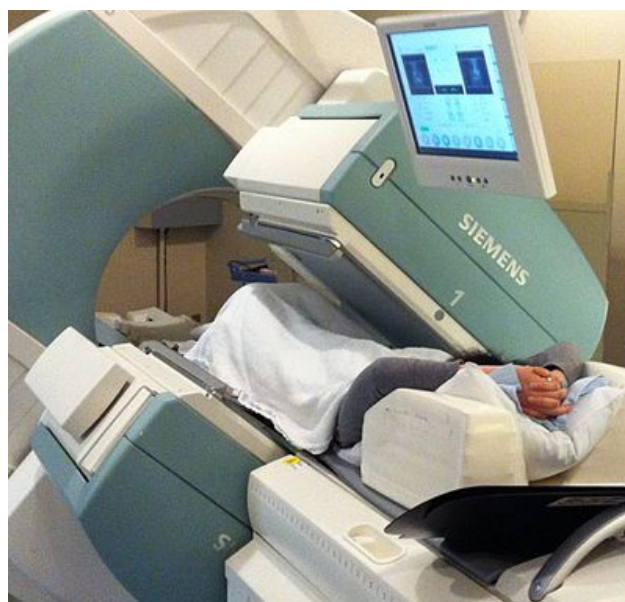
Lung ventilation SPECT were performed with 3 collimators, HR, UHR, and AP, in low (7 kcpv) and high (70 kcpv) counting modes
